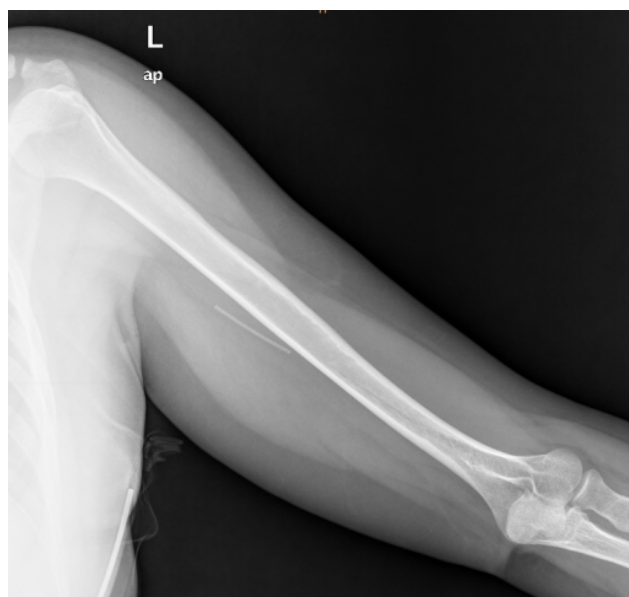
The initial radiography performed to locate the implant shows the migrated device close to the humerus. A CT scan was subsequently performed to ensure no vascular or nervous structures were affected. Barium sulfate in Implanon-NXT® and Nexplanon® allows their identification using ultrasound, radiography, CT, and magnetic resonance imaging.
